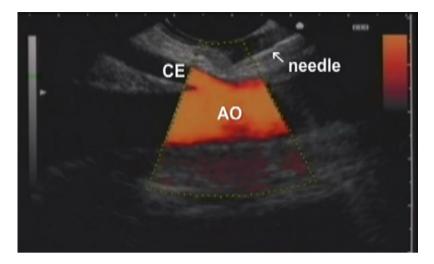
Linear-array EUS imaging using doppler guidance for celiac plexus neurolysis in a patient with pancreatic cancer. AO aorta, CE celiac trunk.
